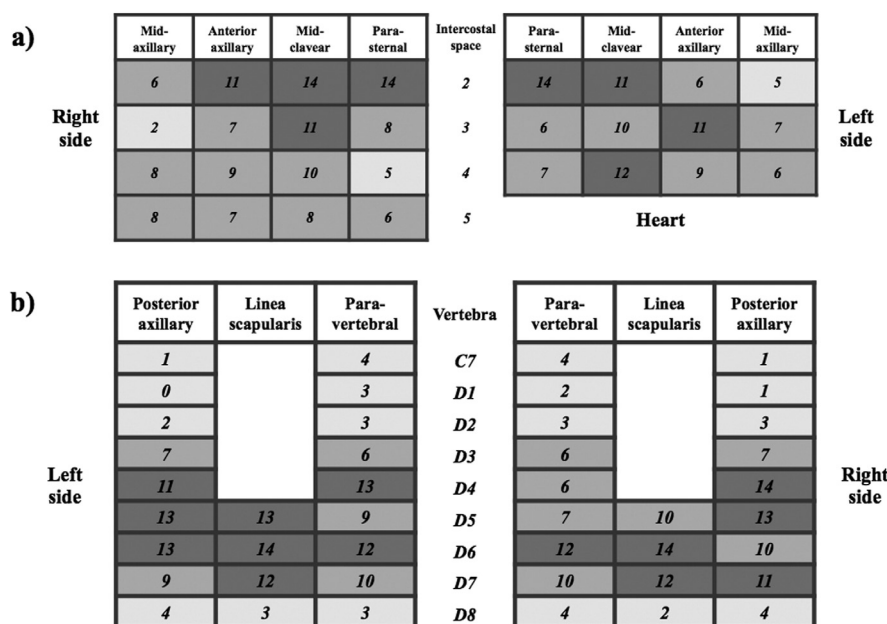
Anatomic distribution of the B-lines. Each field contains the absolute frequency of positive sonographic points of our sample of patients. Lower posterior and upper anterior areas were the most often affected.
